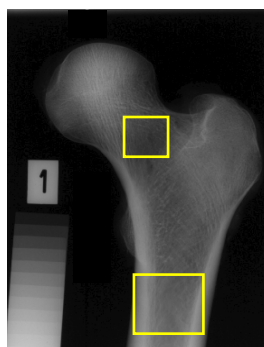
The analyzed ROIs in the radiograph of the proximal femur.
